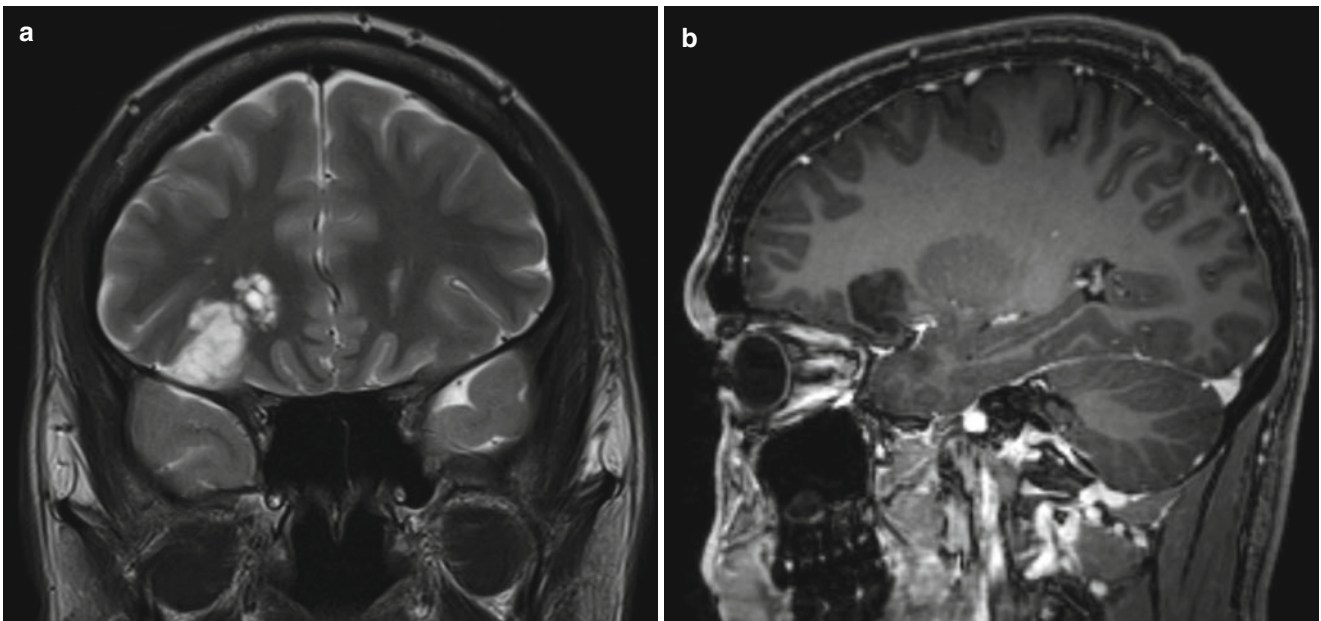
Two patients with DNET. (a, b) patient 1. (a) coronal T2; (b) sagittal T1 with gadolinium; well-delineated cortical/subcortical bubbly mass in the right frontal lobe with prolonged T2 and no contrast enhancement typical of a DNET. (c, d) patient 2: (c) sagittal T1; (d) coronal T2/FLAIR. This DNET in the left parietal lobe is associated with a FCD type II. Notice the streak with signal changes which stretches toward the lateral ventricle
